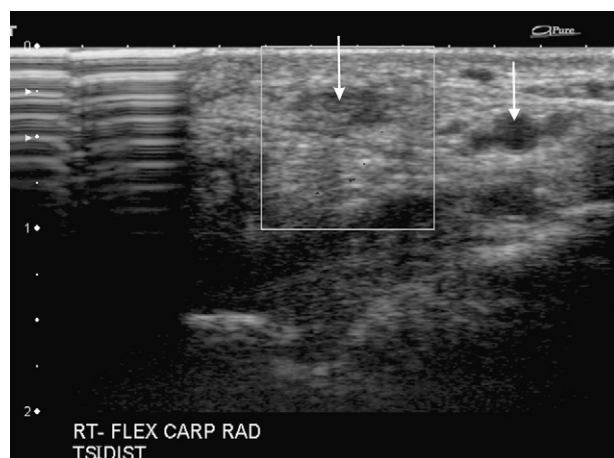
Close up longitudinal ultrasound section of the FCR fascial sheath showing the tendon rupture.
